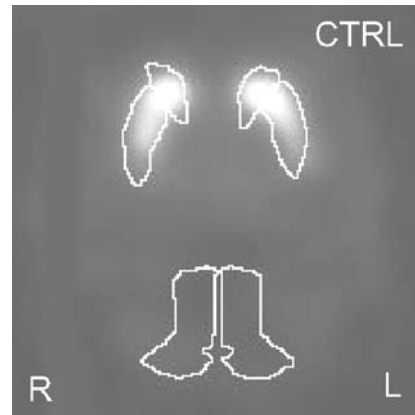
[^{123}I] β -CIT SPECT image of a healthy volunteer. A standard anatomical ROI template (constructed according to a stereotactic atlas and including regions for caudate nucleus, putamen and occipital cortex) has been placed bilaterally. Transverse slice from the brain at the level of the striatum (approximately 3 cm above the orbitomeatal line). Levels of SPECT activity are coded from low (black) to high (white) and have been scaled to the maximum pixel value in the image
